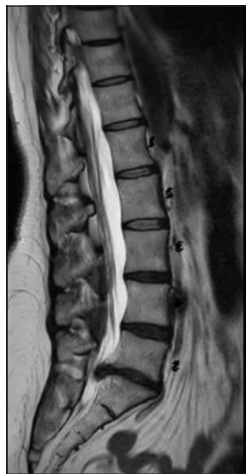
Sagittal T2 magnetic resonance imaging demonstrating massive L5S1 disc herniation.
